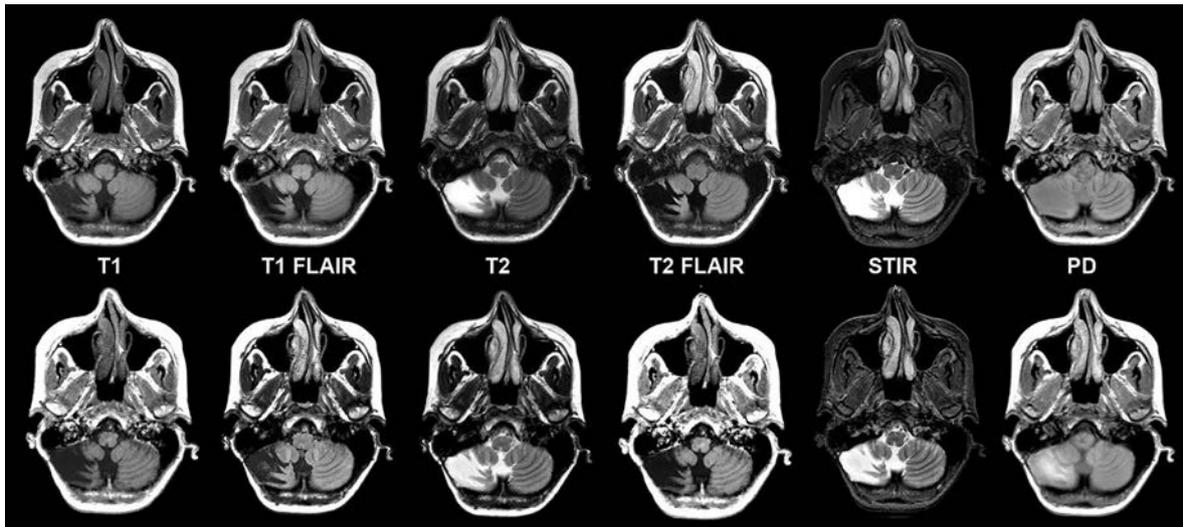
Chronic right cerebellar infarction in a 37-year-old woman on axial synthetic and conventional 3T MR imaging. Conventional (*upper row*) and synthetic (*lower row*) image sets exhibit similar legibility and quality.
